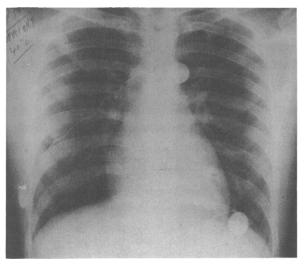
Chest radiograph on fifth hospital day. Lung fields clear except for the possibility of a left sided retrocardiac infiltrate. Diaphragm above 10th rib posteriorly. Vital capacity 2.85 liters; alveolar volume 3.99 liters.
